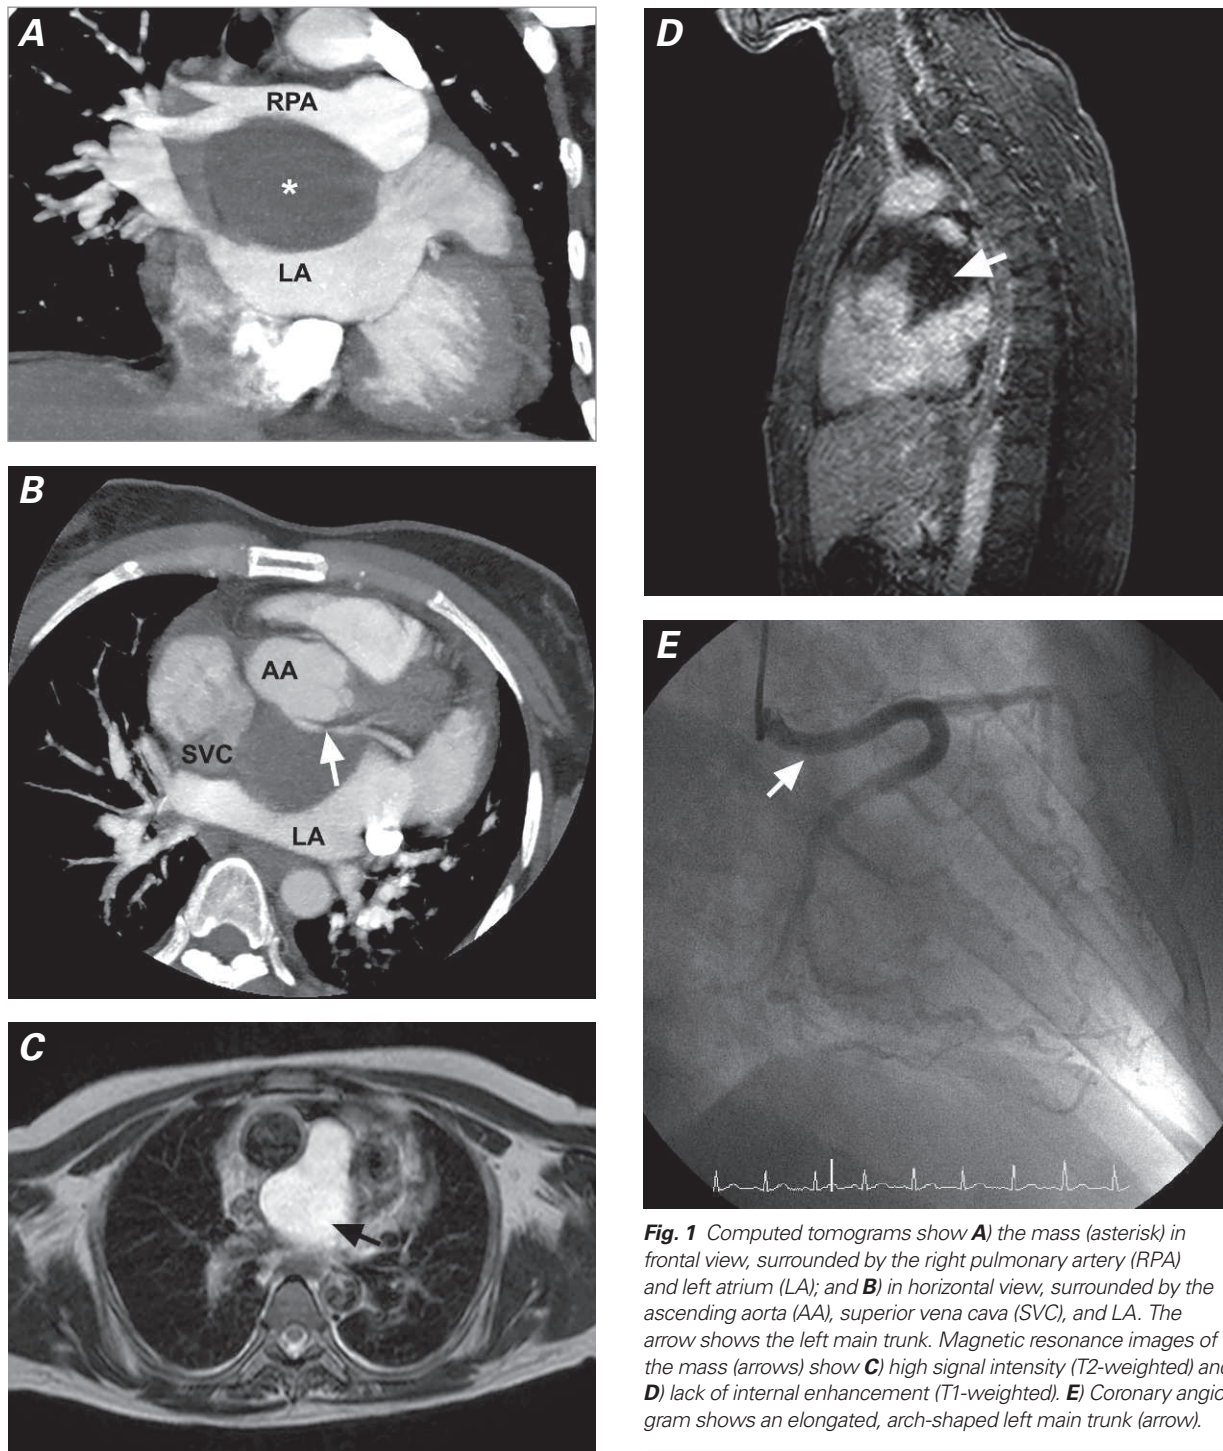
Computed tomograms show A) the mass (asterisk) in frontal view, surrounded by the right pulmonary artery (RPA) and left atrium (LA); and B) in horizontal view, surrounded by the ascending aorta (AA), superior vena cava (SVC), and LA. The arrow shows the left main trunk. Magnetic resonance images of the mass (arrows) show C) high signal intensity (T2-weighted) and D) lack of internal enhancement (T1-weighted). E) Coronary angiogram shows an elongated, arch-shaped left main trunk (arrow).
